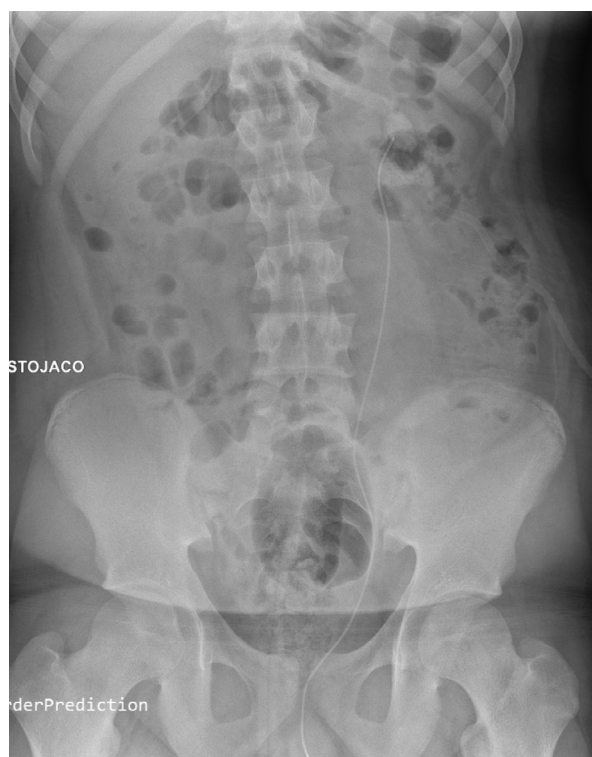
An X-ray image – the patient after percutaneous nephrolithotripsy with visible nephrostomy and JJ catheter
